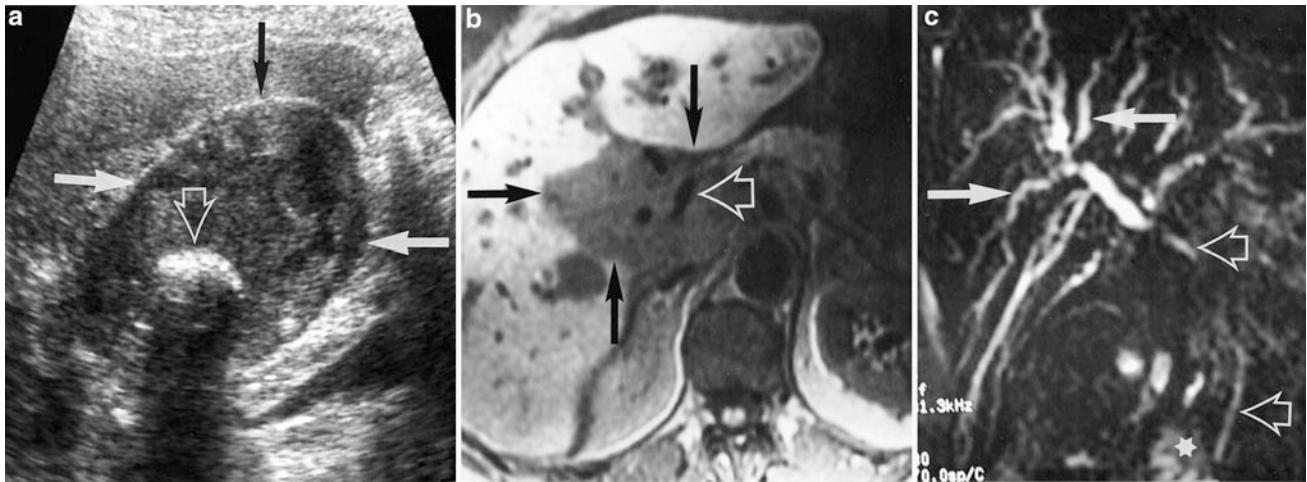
Gallbladder carcinoma. a Sonography reveals tumorous tissue replacing the gallbladder (arrows). A gallstone is also seen (open arrow). b MRI (T1 fat-saturated gradient echo) shows tumorous tissue even in the hilar area (arrows). There are vessels inside the tumorous
